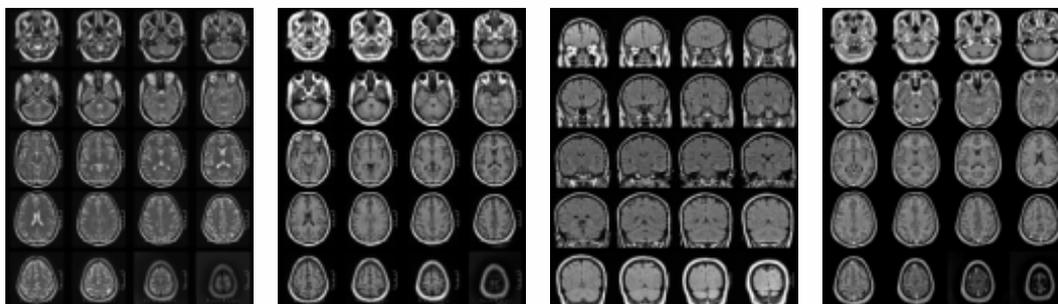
MRI brain with contrast
